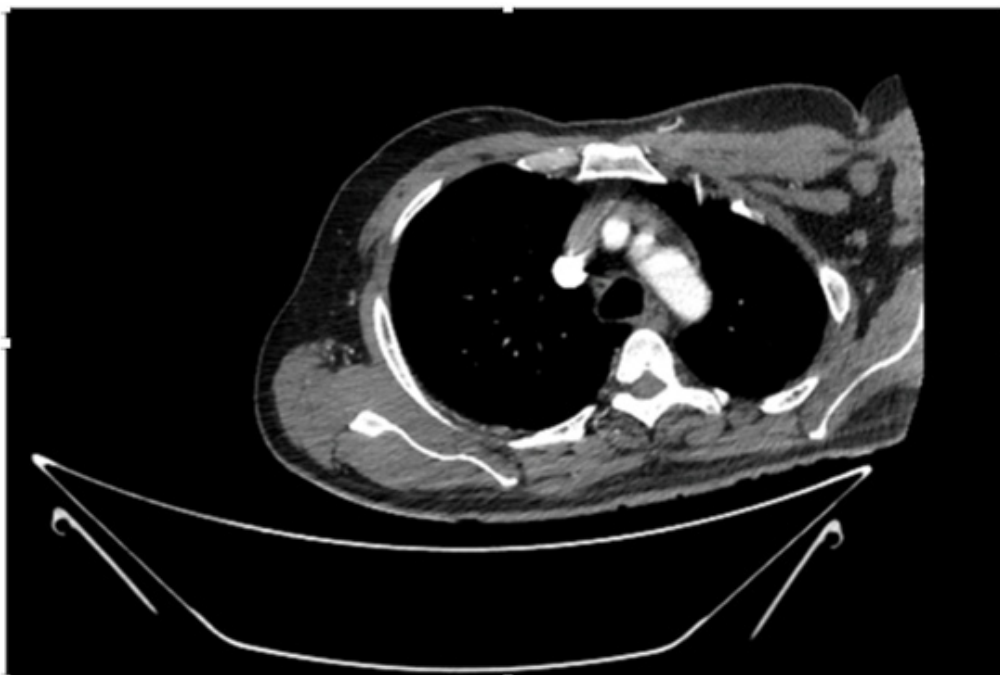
CT Angiogram at thorax showing normal main trunk.
